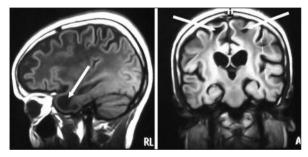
MRI, when compared to the one obtained two years earlier, showed minimal increase in diffuse cerebral atrophy and slightly enlarged temporal and frontal subcortical cysts (arrows on A, T1 weighted sagittal and B, FLAIR coronal images).
